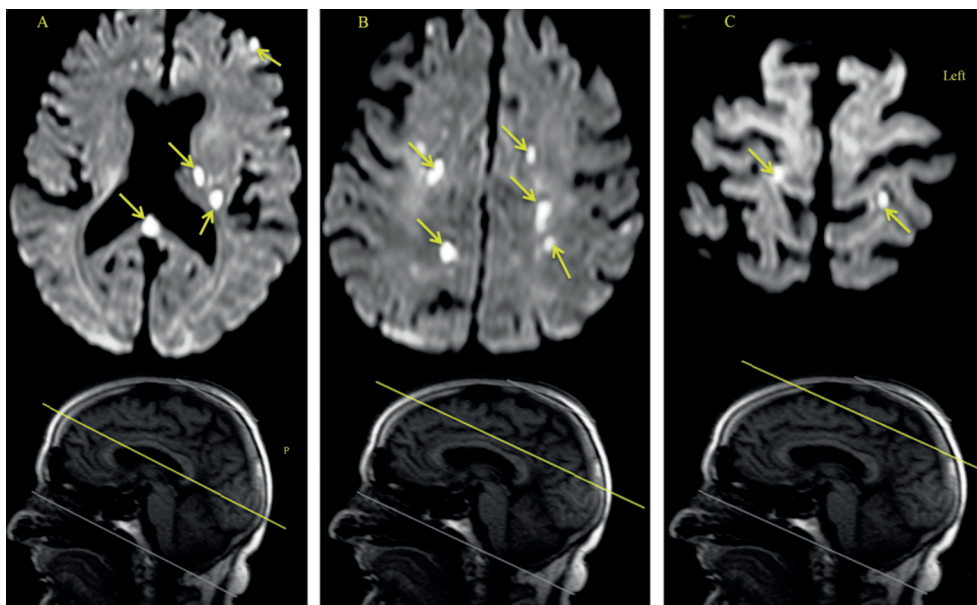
Periprocedural lesion detected on post- TAVR MRI. The lesion typically appears brighter on DWI sequence.
